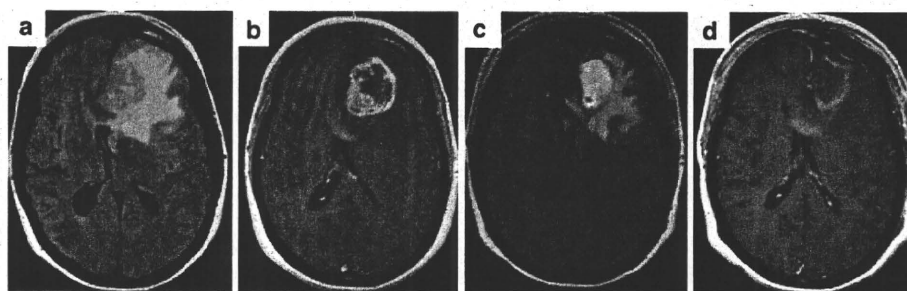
a, b FLAIR (a) and T1-weighted MRI of brain with gadolinium (Gd)-contrast (b) axial sections showing a left frontal mass and an anterior corpus callosum lesion with surrounding edema.
